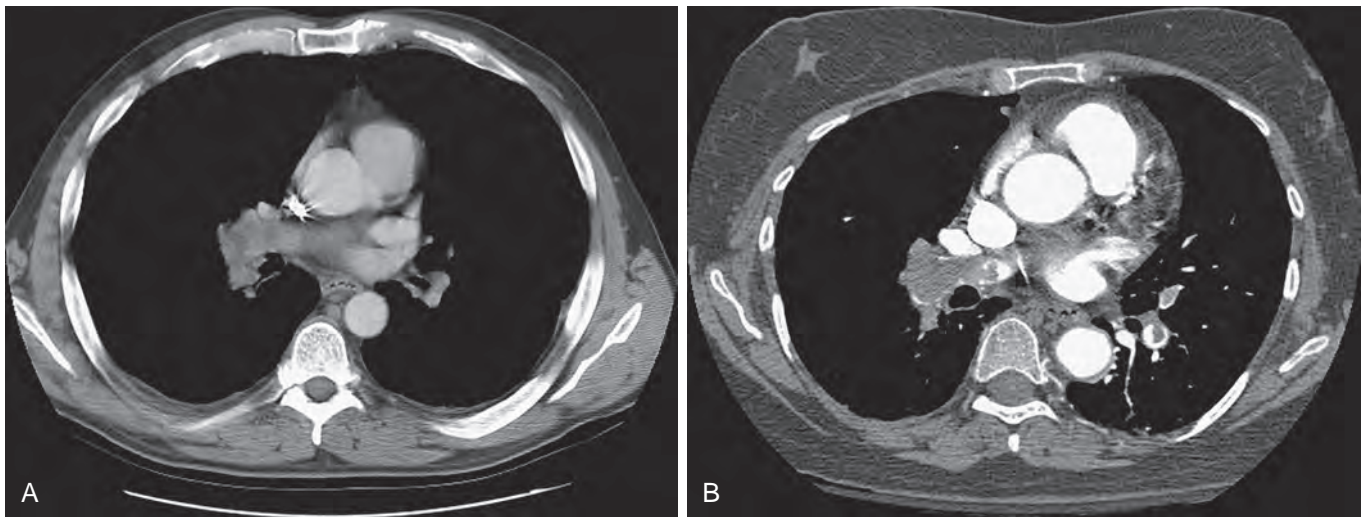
Pulmonary tumor embolism with renal cell carcinoma. (A) Computed tomography angiogram (CTA) of the chest shows a large saddle-tumor thrombus in the main pulmonary artery. (B) A CTA of a second patient with extensive, occlusive tumor thrombus in the right main pulmonary artery and in the branches of the left pulmonary artery tree. (Reproduced with permission from Mayo Foundation for Medical Education and Research. All rights reserved. Reprinted in Kayalar N, Leibovich BC, Orszulak TA, et al. Concomitant surgery for renal neoplasm with pulmonary tumor embolism. *J Thorac Cardiovasc Surg.* 2010;139:321.)
